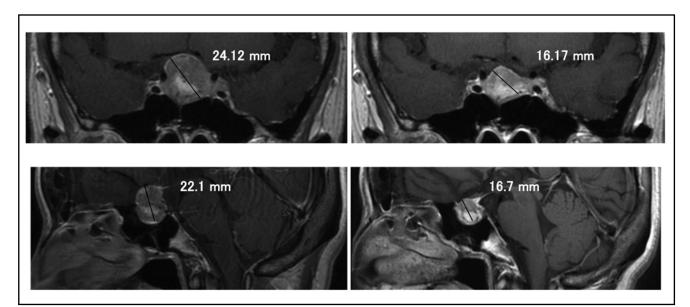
Case 2. Magnetic resonance imaging using gadolinium-based contrast medium. The tumor measured 24 mm before treatment but shrank to 16 mm at six months after administration of lanreotide.
